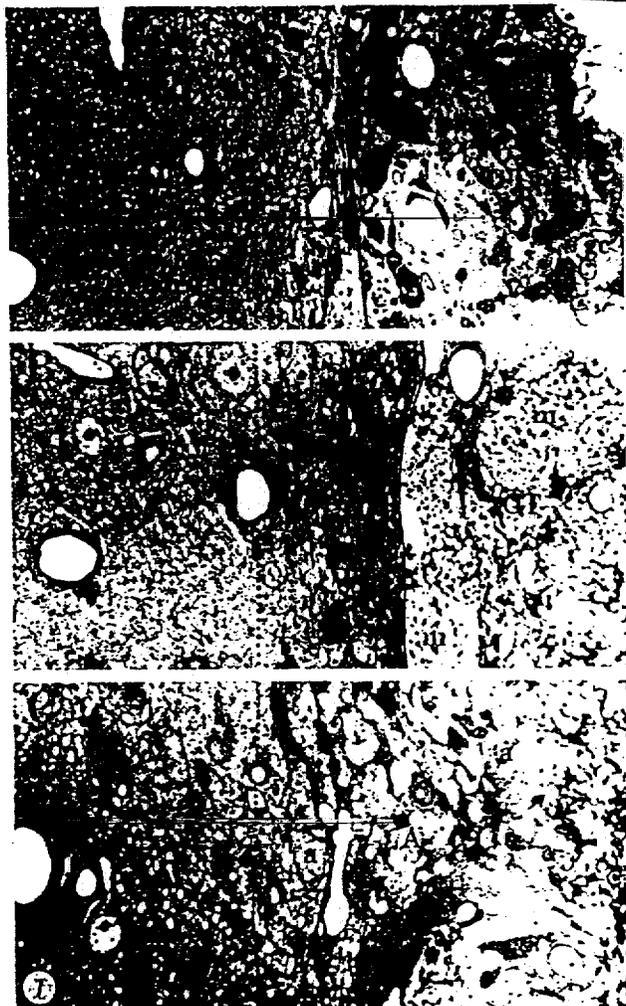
The complex boundary surrounding toxic implants: iron (A), copper (B), and cobalt (C). Altered cerebral cortex surrounds the zone of astrocytosis (A). Macrophages (m) and giant cells (gc) are situated in the zone of connective tissue (CT) near iron and copper implants. Calcium (ca) and hypertrophic astrocytes (a) occur in the zone of astrocytosis near the cobalt implant. Iron (188 days), copper (192 days), and cobalt (270 days). $\times 400$
